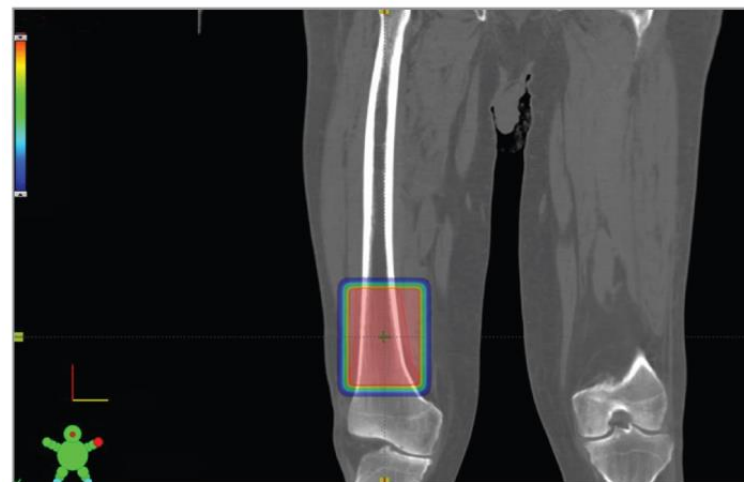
Coronal CT through a lesion in the right distal femur. The radiation dose (blue line) as a function of depth of penetration into the body for FLASH delivery with a 250 MeV proton beam [13].
